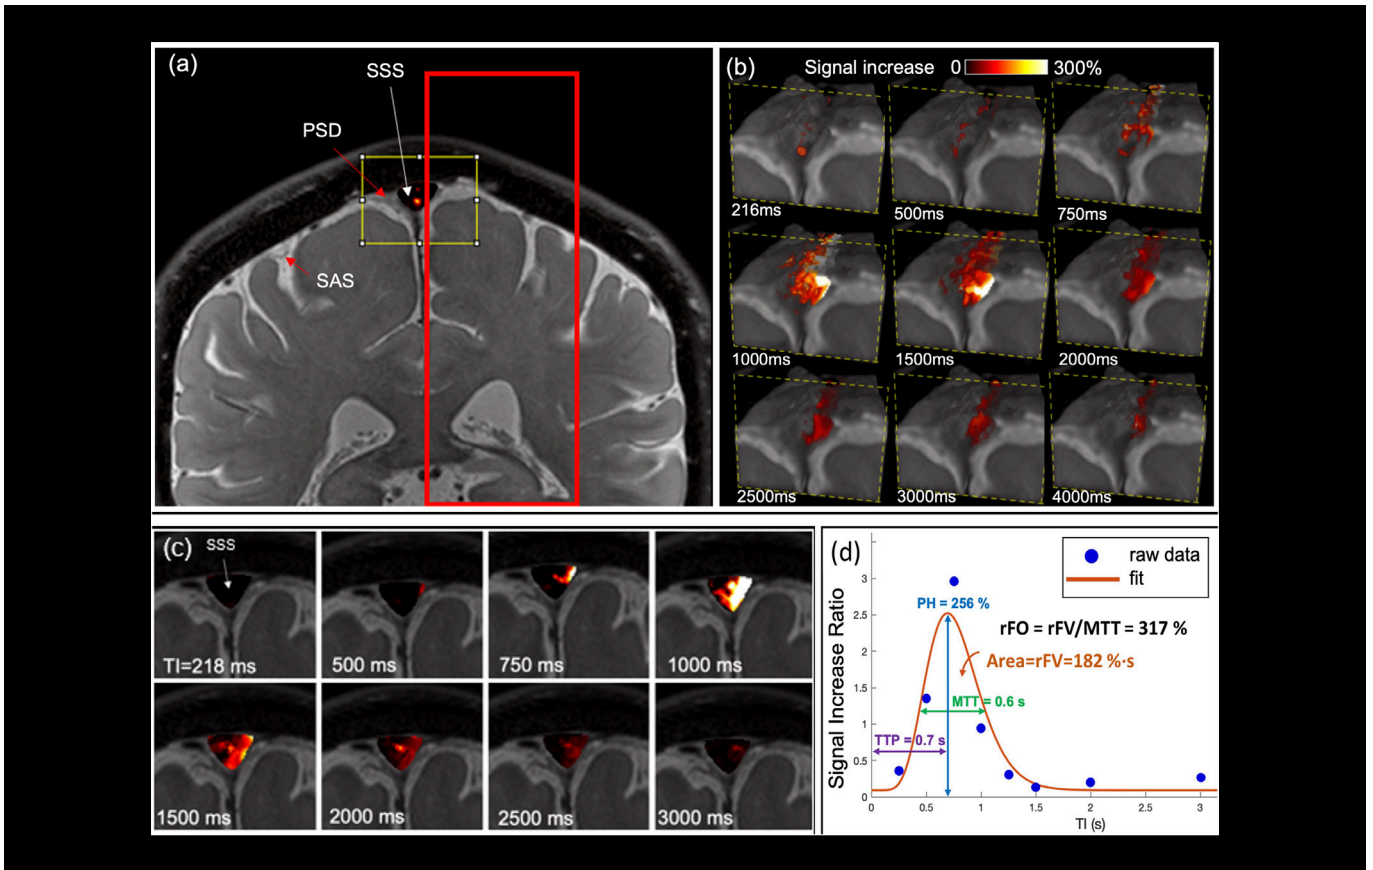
a) Coronal 3D cSSFSE image with a spin labeling tag pulse (red box). The Time-SLIP tag pulse is placed about 10 mm away from the superior sagittal sinus (SSS). b) A series of oblique 3D spin labeling images with various inversion times (TIs) fused over 3D cSSFSE image, enlargement of yellow box in a). Note that the tagged signals increase from the Time-SLIP on the left brain at the parasagittal dura (PSD) region at TI of 500 ms and then disappear or egress into the SSS by 1500 ms. c) Straight coronal fusion images of tagged MRI signals around the SSS region over 3D cSSFSE images at various TIs show tagged fluid outflow from the tag pulse to dura mater and PSD into the SSS. d) Tagged CSF outflow signal at the SSS. Circles show the data points, and the line indicates the curve fit. Peak height (PH) is 256%, mean transition time (MTT) is 600 ms, time to peak (TTP) is 700 ms, relative fluid volume (rFV) is 182 %·sec, and relative fluid outflow (rFO) is 317 %, obtained by dividing rFV by MTT.
